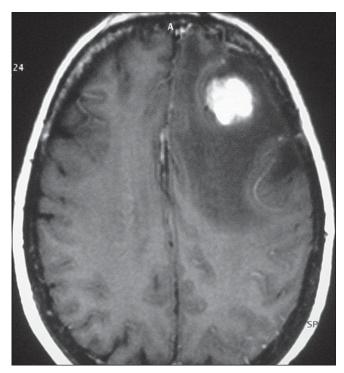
MRI brain showing uniform enhancement on contrast in the lesion
